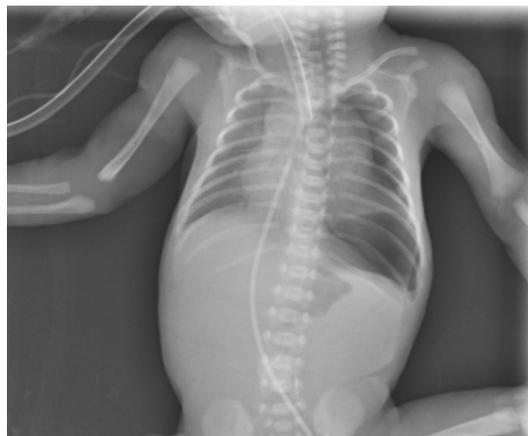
First radiograph after orogastric tube placement, which was not visualised, showing a left-sided pneumothorax.
